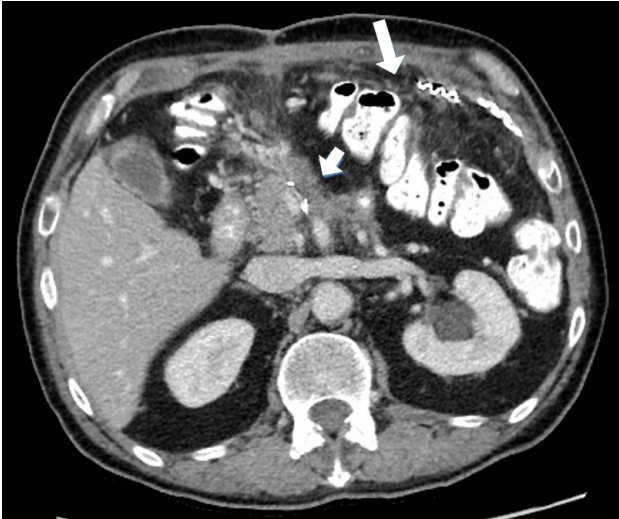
Contrast enhanced CT shows local recurrence at the borders of left pancreatectomy (short arrow) as well as tiny peritoneal infiltrations (long arrow). Metallic foreign bodies in the anterior aspect of the left upper quadrant, right posterior to the anterior abdominal wall, represent drainage tube remnants previously inserted to treat post-operative complication.
